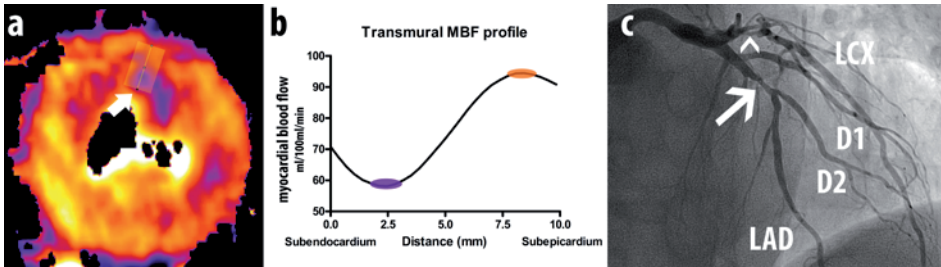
TPR case example: 65-years-old man presenting after exertional collapse. a) Short-axis CT-MPI image with the transmural perfusion line placed in the anterior-lateral segment. (white arrow). b) The transmural MBF profile. The subendocardial MBF was 58ml/100ml/min (purple marker), and 91ml/100ml/min in the subepicardium (orange marker). The TPR was 0.64 (58/91), and thus considered positive for ischemia. c) Invasive angiography showing a stenosis in the proximal LAD with an FFR of 0.69. A subtotal stenosis was directly stented in the LCX (arrow head), as such no FFR measurement was performed. In panel a however a perfusion defect with a transmural perfusion ratio can be seen in the territory associated with the LCX. The RCA was normal with an FFR of 0.91. RCA: right coronary artery, LAD: left anterior descending artery, LCX: left circumflex artery, TPR transmural perfusion ratio, MBF: myocardial blood flow, FFR: fractional flow reserve.
